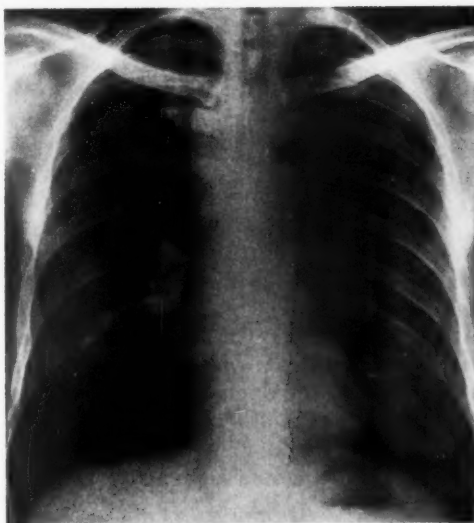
Roentgenogram of chest, showing definite decrease in mediastinal widening following radiotherapy.
